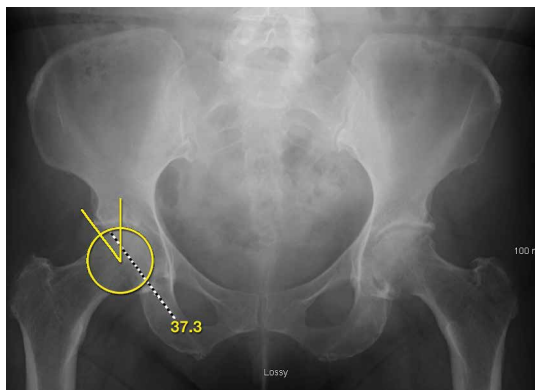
Anteroposterior pelvis radiograph of a 39-year-old woman shows no significant patient rotation or tilt. Measured angle is lateral center-edge angle, or angle between 2 lines from center point of femoral head. One line is straight vertical radius of circle; other is oblique line to superolateral-most aspect of acetabular sourcil. In this case, lateral center-edge angle is 37° (normal, 20°-40°).
